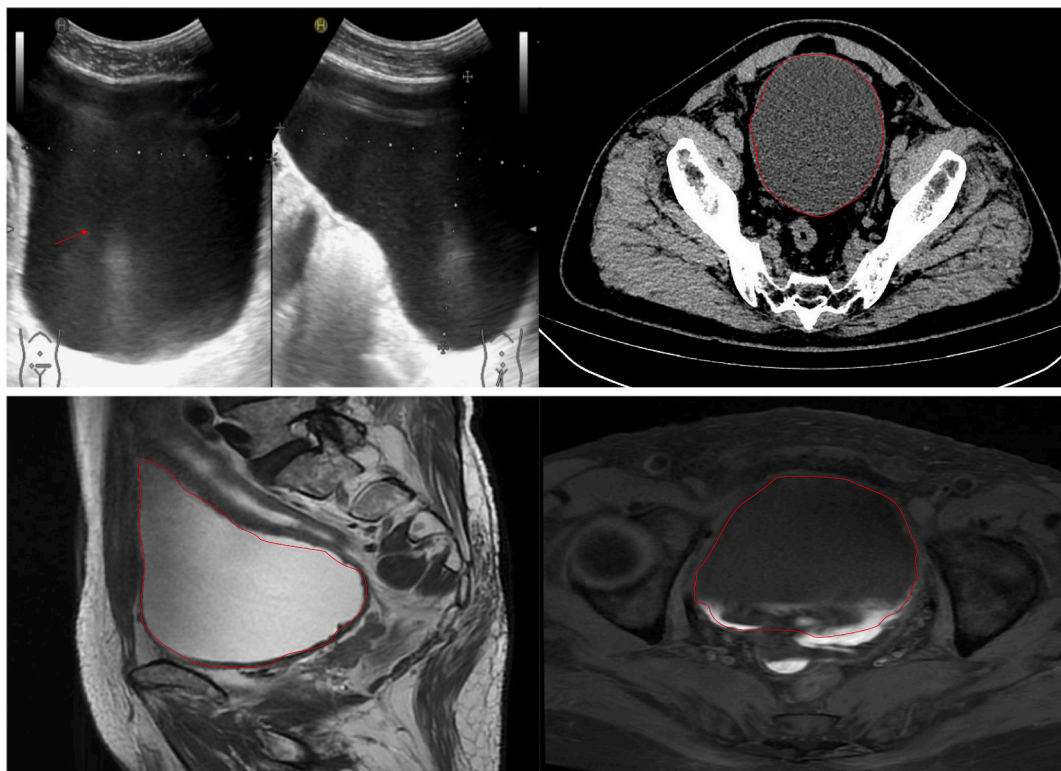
Representative image demonstrating urine retention: (Top left) B-scan ultrasonography of a 45-year-old woman developing PUR two weeks after taTME (Top right) Computed Tomography of a 51-year-old male developing PUR three weeks after taTME (Bottom left) (Bottom right) Magnetic Resonance Imaging of a 65-year-old male who was detected chronic urinary retention in preoperative examination and excluded in the research.
